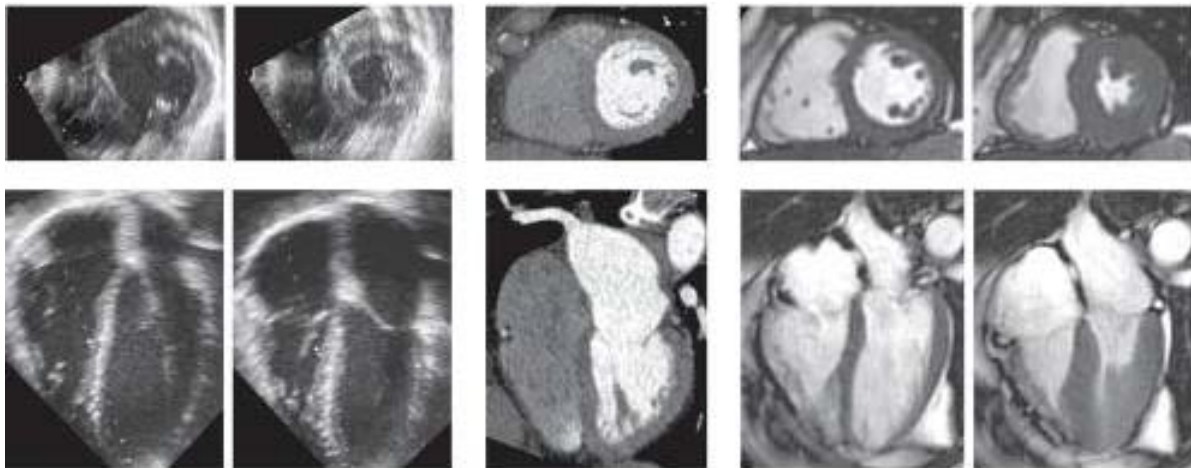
Heart images obtained with three different measurement methods in the short-axis and long-axis views of the heart. At the left, ultrasound images are shown at two different moments in the heart cycle. In the middle, images obtained with a CT-scan are shown. At the right, heart images obtained by MRI are shown, during two moments in the heart cycle. The images are obtained from [101].
